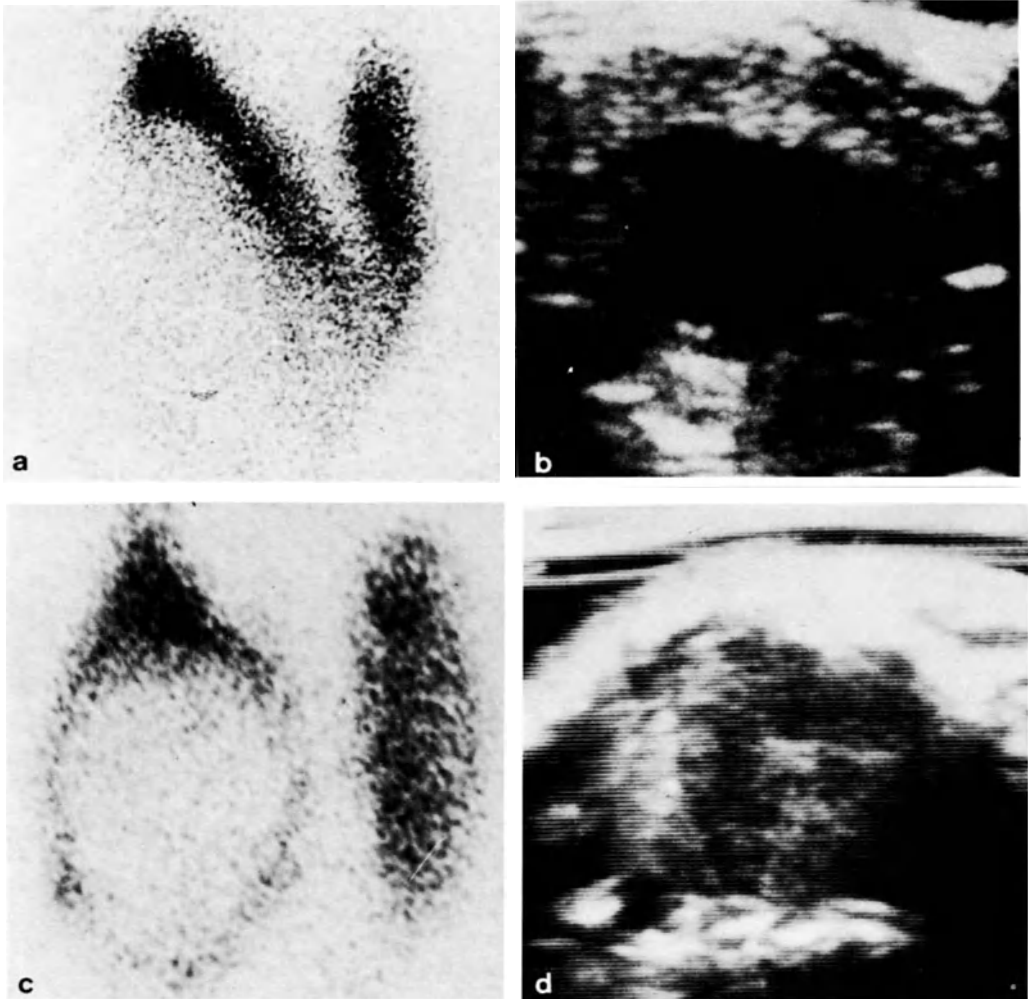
Ultrasound scan of solitary cold nodule. a $^{99}\text{Tc}^{\text{m}}$ scan; b ultrasound scan showing cyst; c $^{99}\text{Tc}^{\text{m}}$ scan; d ultrasound scan showing solid tumour
